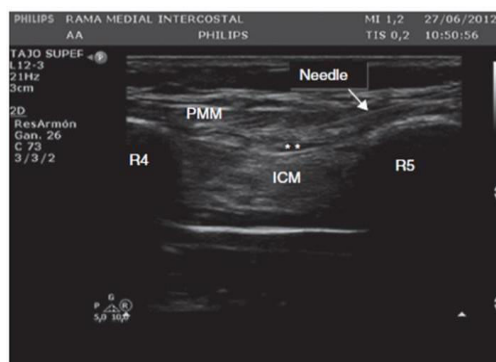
Ultrasound image of PIFB on the anterior chest wall; ICM: intercostal muscles, PMM: pectoralis major muscles, R4: costae 4, R5: costae 5 [16].
